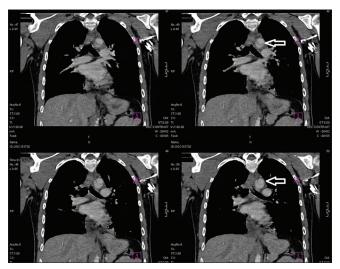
Computed tomography showing the rupture of the aortic isthmus (arrow) with the presence of pseudoaneurysm and mediastinal hematoma
